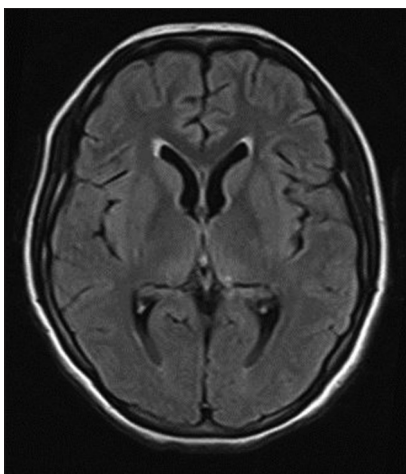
Normal brain magnetic resonance imaging
